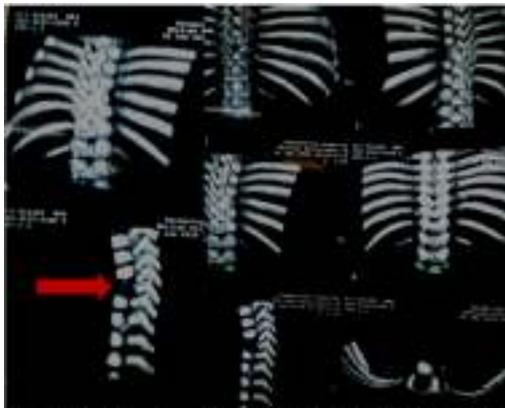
3D reconstruction CT scan of thoracolumbar spine with a defect at thoracic 9 vertebral
